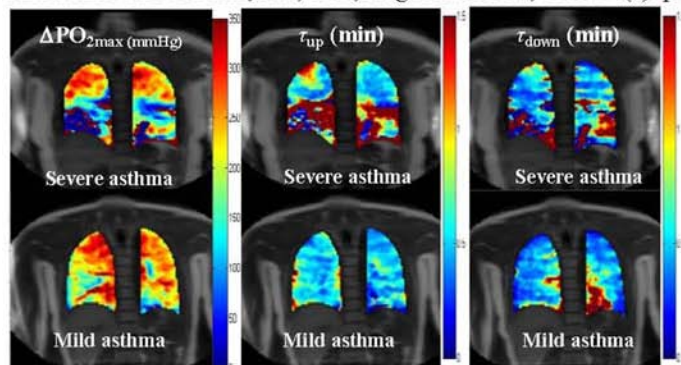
The OE-MRI parameter maps of a severe asthmatic participant (F, 19yrs, FEV<sub>1</sub> % Pred norm. =63.5%) and a mild asthmatic participant (F, 19yrs, FEV<sub>1</sub> % Pred norm.=99.0%).
